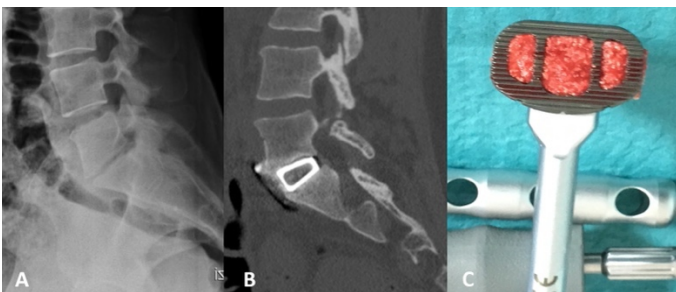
Radiological evidence of collapsed disc height and segmental lordosis restoration after anterior cage implant. A: preoperative lumbar X-Rays showing L5-S1
